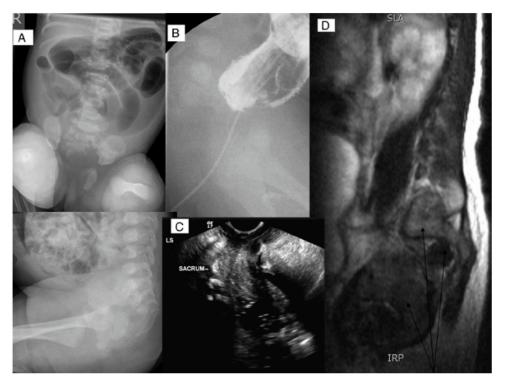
Plain, contrast, ultrasound and MRI showing scimitar hemisacrum, anorectal stenosis and presacral mass (arrows in MRI) [22]
